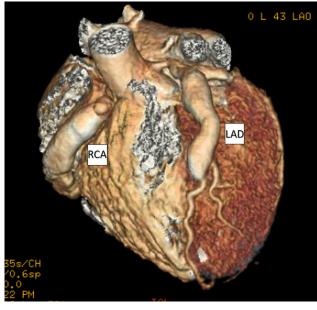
Patient's coronary computed tomography (CT) angiogram showing giant coronary artery aneurysms of both the left and right coronary arteries. (RCA: right coronary artery; LAD: left anterior descending)
